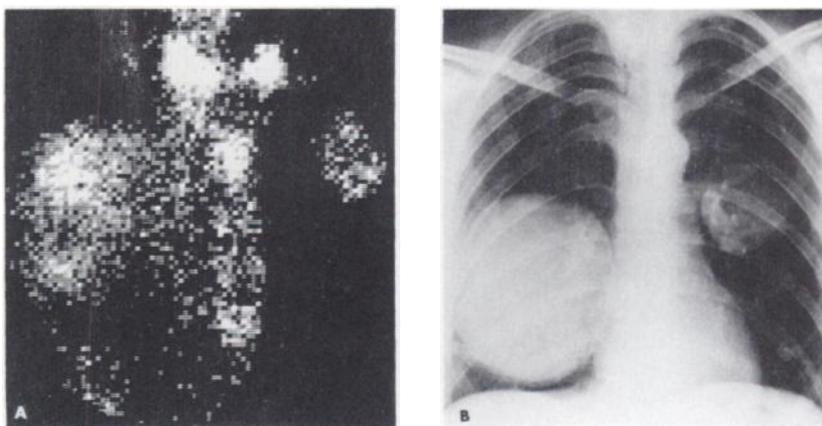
(A) Anterior chest scan using ^{99m}Tc -pyrophosphate. In addition to sternal uptake, which is particularly well defined in sternoclavicular and manubriosternal joint regions, there are two areas of extraosseous ^{99m}Tc localization within lung fields. (B) Chest radiograph, taken 6 days after bone scan, shows well-defined tumors in lungs.
